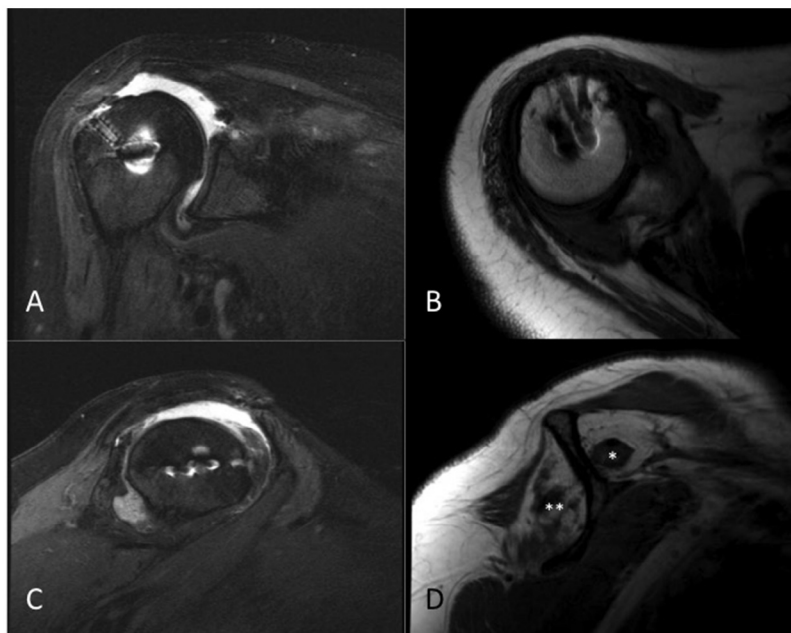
Preoperative (before nerve transfer and reverse shoulder arthroplasty operations) magnetic resonance images. (A) T2 coronal image demonstrates recurrent tear of the superior rotator cuff with proximal humeral migration. (B) A T1 axial image demonstrates previous anchors and deltoid atrophy. (C) A T2 sagittal image shows complete tear of the supraspinatus and infraspinatus tendons. (D) A T1 sagittal image establishes the substantial atrophy and fatty infiltration of the supraspinatus fossa (*) and infraspinatus fossa ().
